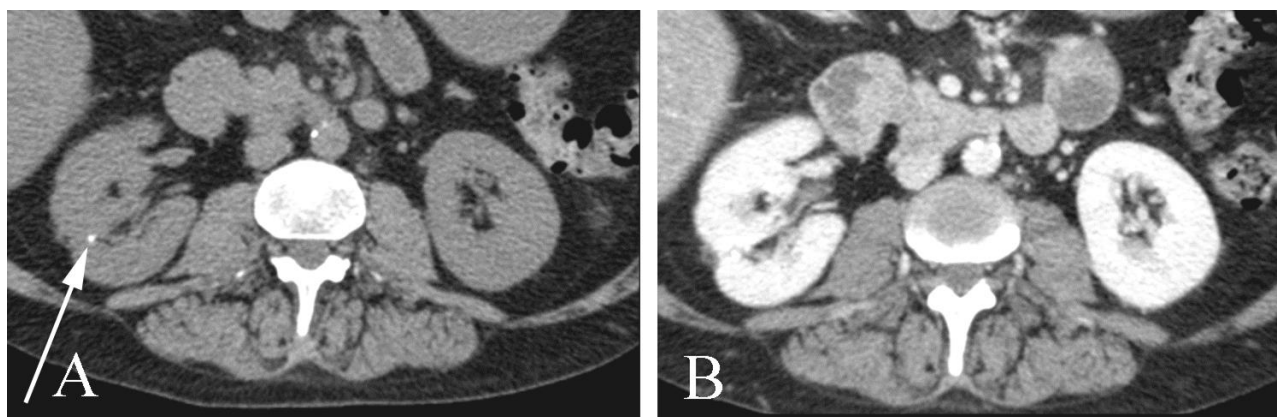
Renal stone associated in a 50 year old woman with hematuria. A. Precontrast (unenhanced) CT clearly shows a nonobstructing right renal stone (arrow). B. On the postcontrast CT, contrast material largely obscures the stone. If only the postcontrast CT had been performed, the stone would be very difficult (if not impossible) to recognize.
